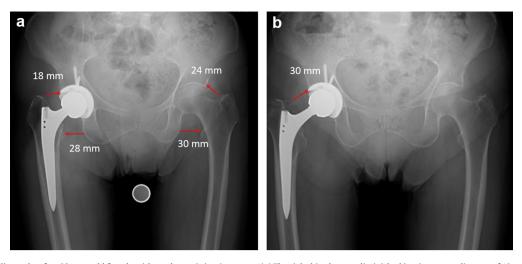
AP pelvis radiographs of an 82-year-old female with trochanteric impingement. (a) The right hip shows a diminished impingement distance of 18 mm compared to 24 mm on the contralateral hip. The offset of the right hip (28mm) is slightly less than the left (30 mm). (b) Postoperative findings demonstrate an increased impingement distance of 30 mm accomplished by exchange to a +12 head from a +0 head.
